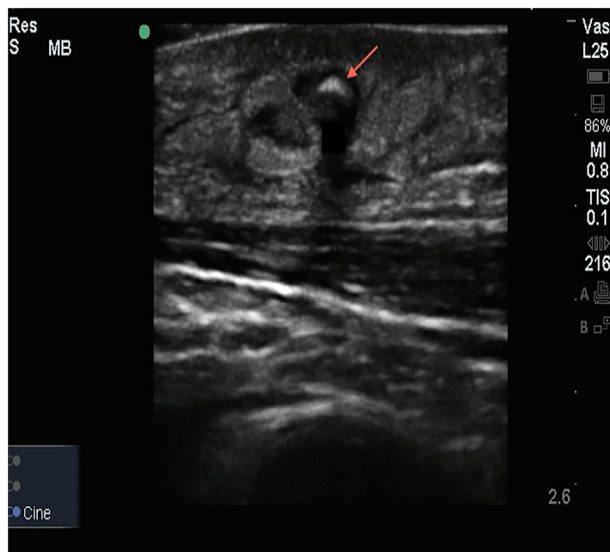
Ultrasound images of skin lesion containing cutaneous bot fly larva (arrow) with posterior shadowing and surrounding inflammatory changes (cobblestone appearance) but no abscess cavity.
